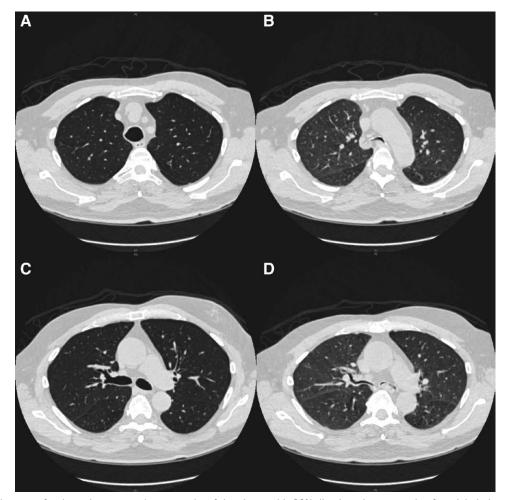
Axial images of a dynamic computed tomography of the chest, with 80% distal trachea narrowing from inhalation (A) to exhalation (B), and 86% right and 98% left main bronchus narrowing from inhalation (C) to exhalation (D).
